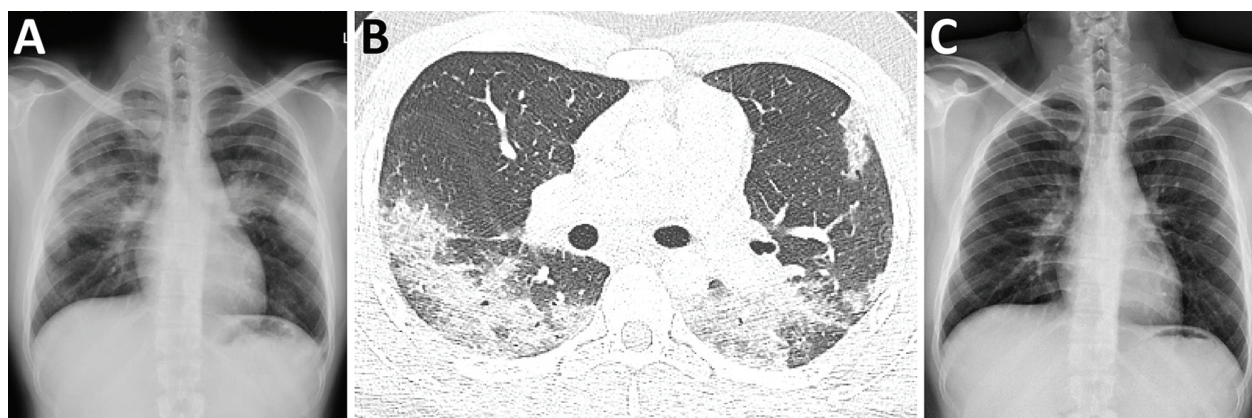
(A) Chest posteroanterior radiograph showing infiltration and opacity in bilateral lungs; (B) High-resolution computed tomography axial and reformatted coronal view revealed consolidation patches and ground-glass opacities in both lungs; (C) Chest posteroanterior radiograph after 16 days of systemic steroid treatment.
